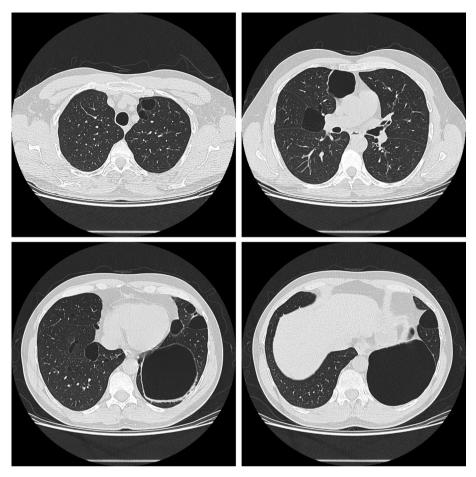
Patient's presenting CT scan of the thorax demonstrating multiple, lobulated, septated bilateral cysts in varying sizes and shapes with a basal predominance.
